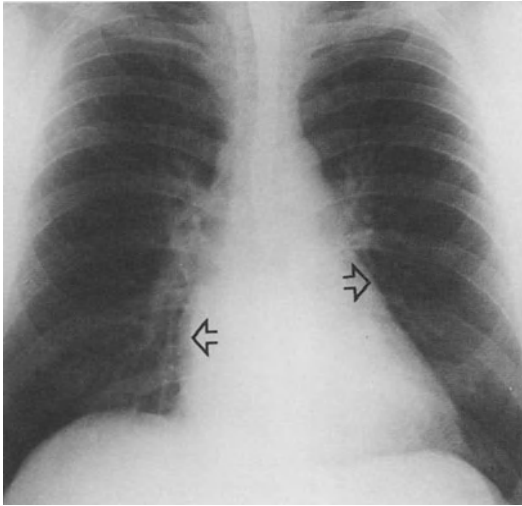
The X-ray in mitral stenosis demonstrating enlargement of the left atrium in the frontal view (left) manifested as a straightening of the left cardiac border and a double density within the right
